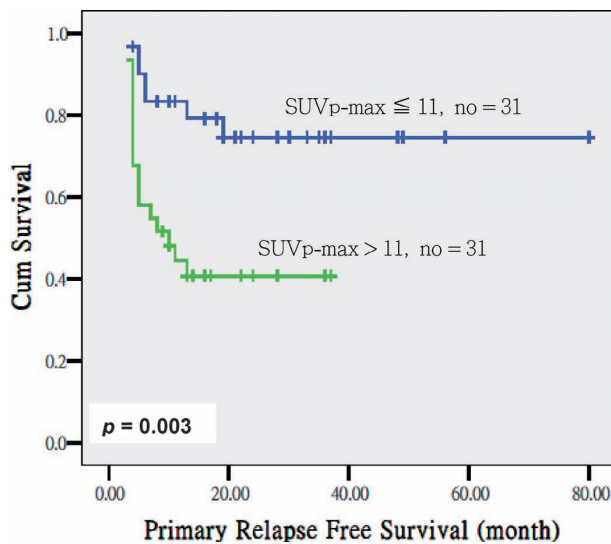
Primary relapse-free survival according to the SUV_p-max > 11 and ≤ 11 .
